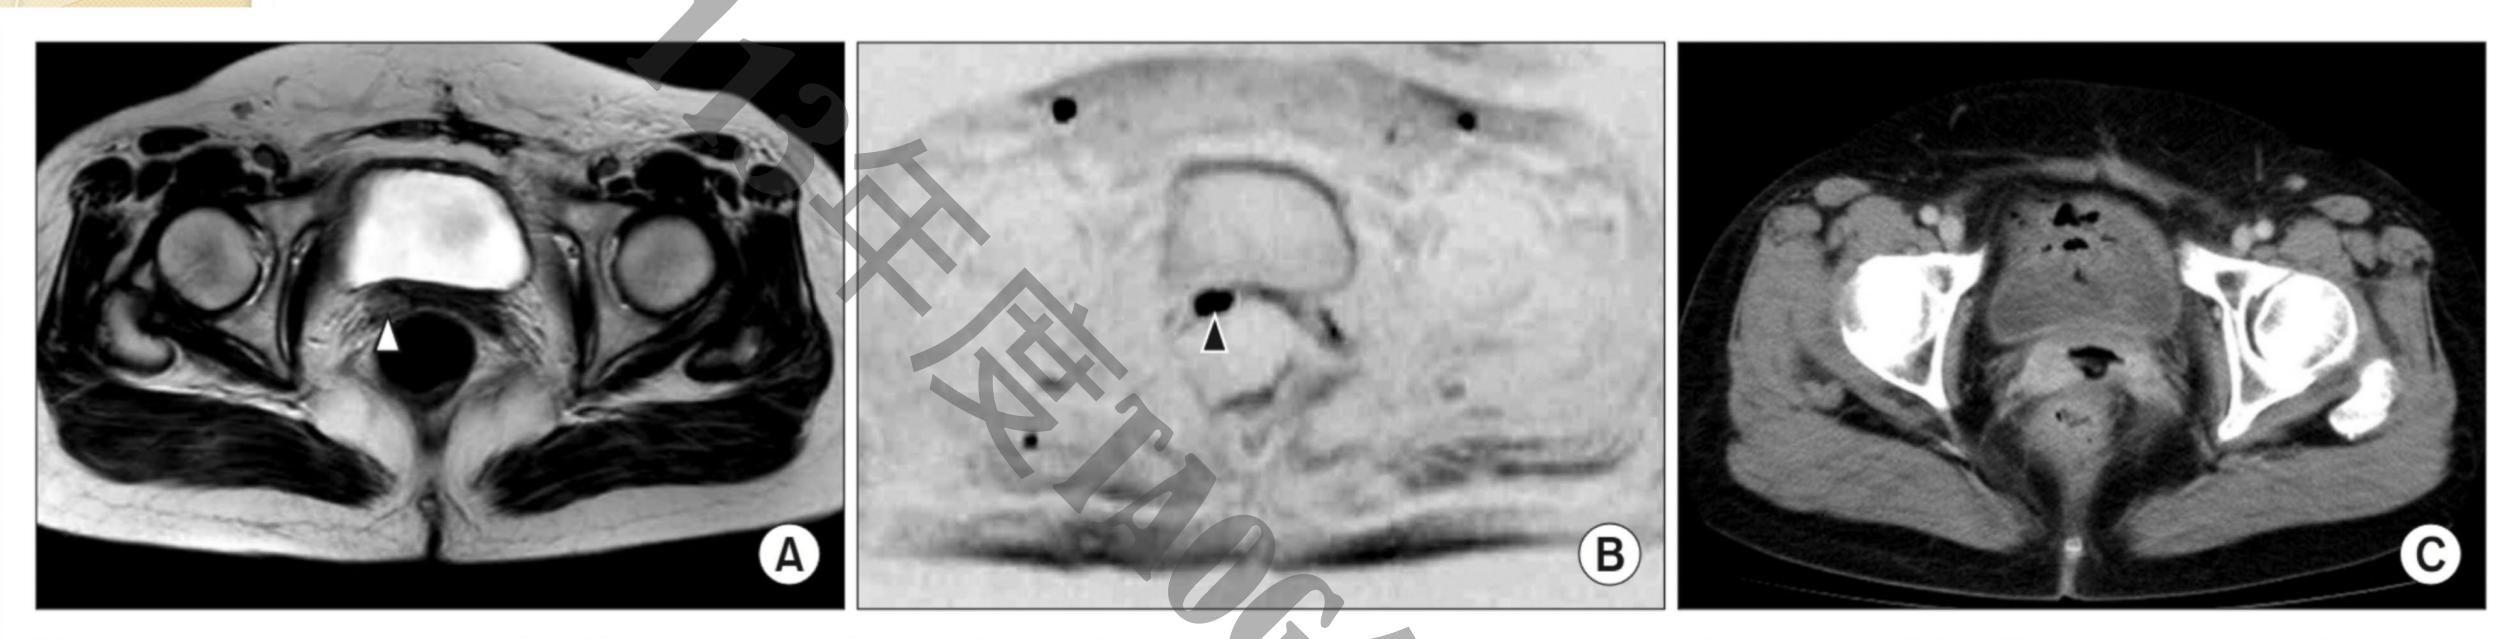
Postoperative vaginal cuff recurrence of stage IVB endometrial carcinoma in a 66-year-old woman. Axial T2-weighted imaging shows a slightly high-signal lesion (arrowhead) on the right side of vaginal cuff (A). Axial diffusion-weighted imaging clearly depicts the lesion (B) and the apparent diffusion coefficient (ADC) map (not shown) demonstrated low ADC values (0.91×10⁻³ mm²/sec). The lesion is difficult to distinguish on contrast-enhanced-computed tomography (C).
